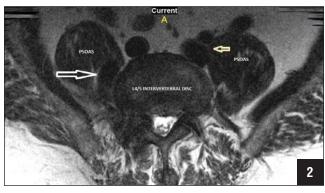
Axial magnetic resonance image at L4-L5. Right internal iliac remains between the psoas muscle and vertebral body (right arrow).
